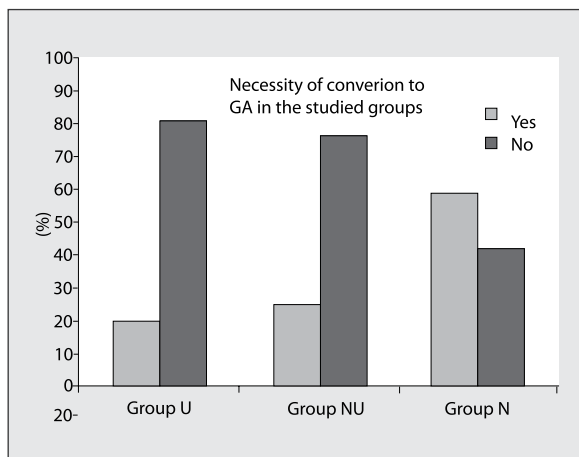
Necessity of conversion to general anesthesia in the U (interscalene brachial plexus block with ultrasound guidance), NU (interscalene brachial plexus block with ultrasound guidance and peripheral nerve stimulator confirmation), and N (interscalene brachial plexus block with peripheral nerve stimulator confirmation) groups
